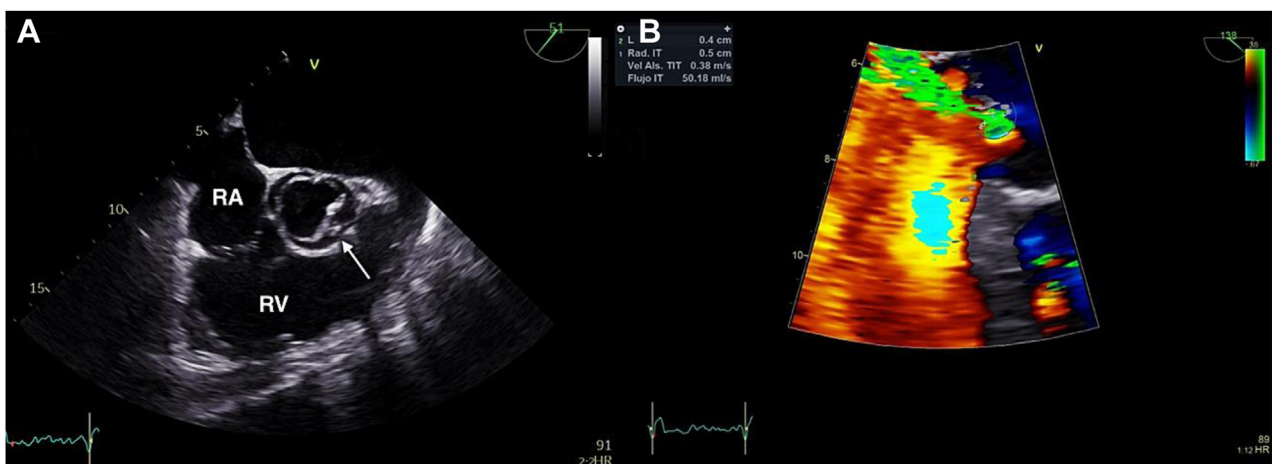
(A) Two-dimensional TEE, midesophageal short-axis (51°) view, midsystolic phase, demonstrates BAV with raphe between right and left coronary leaflet (*white arrow*). (B) Two-dimensional TEE, midesophageal long-axis (138°) view with color-flow Doppler focused on the aortic valve, systolic phase, demonstrates a moderate regurgitation jet (PISA radius, 0.5 cm; vena contracta, 0.4 cm). RA, Right atrium; RV, right ventricle.
